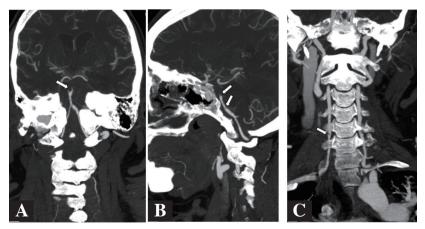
CT angiogram with (A) coronal reconstruction showing upper basilar thrombus (arrow) (B) sagittal reconstruction showing large upper basilar and small eccentric mid-basilar thrombi (arrows) (C) coronal reconstruction showing eccentric thrombi (arrow) in the V2 segment of right vertebral artery
